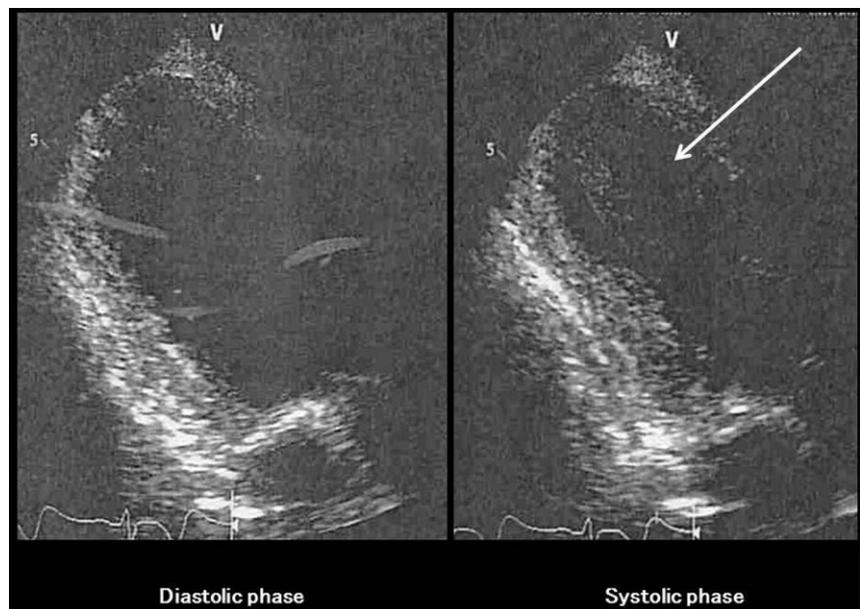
Echocardiogram of a 76-year-old woman, taken on arrival at the emergency department, who was unconscious and normotensive, with right hemiplegia and chemical burns. The echocardiogram revealed left ventricular apical akinesia (arrow) and basal hyperkinesis characteristic of takotsubo cardiomyopathy, which was not associated with the coronary artery distribution.
